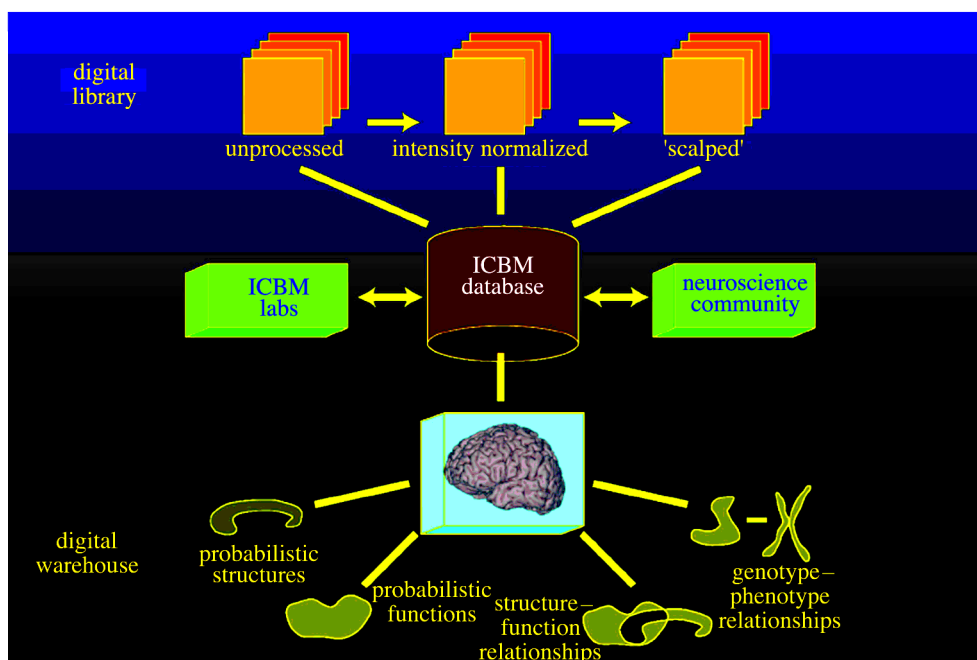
Digital libraries and data warehouses. We envision two outputs of the probabilistic atlas to the neuroimaging and neuroscientific communities. The first is termed 'digital libraries'. In these libraries we will catalogue complete MRI studies from large numbers of subjects. They will be held in three forms: raw data (with the face corrupted for confidentiality reasons); intensity normalized images; and 'scalped' intensity normalized images where extracranial tissues have been removed. A user would be able to select a certain list of descriptors (e.g. females, aged 25–30, right-handed) and will be told how many subjects and datasets fulfil this requirement. These datasets can then be transferred (either electronically or through magnetic media, depending on the size) to the requesting investigator. Data warehouses provide database interactions where probabilistic structures and high-level queries can be obtained by interacting with the entire population of 7000 studies or user-selected subpopulations. Such queries can be representational or symbolic and may ultimately be object-oriented. These queries may involve the imaging, clinical, behavioural or genetic data.
